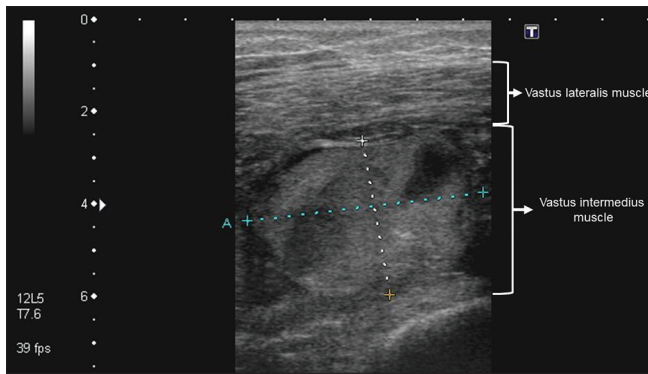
Ultrasonography revealed a 5 cm × 3 cm heterogeneous mass in the left vastus intermedius muscle without pulsatile Doppler signals. Mild edematous changes in the peripheral muscles were also observed. There was no significant edematous change or fluid accumulation in the skin or subcutaneous level
